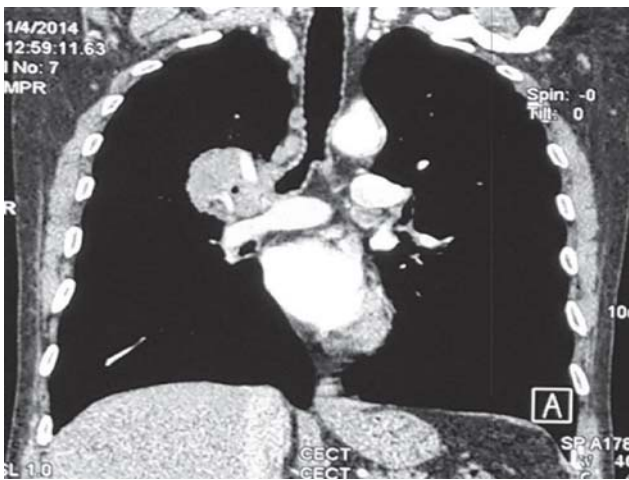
Computed tomography (coronal section) showing large mass encasing the bronchus.
